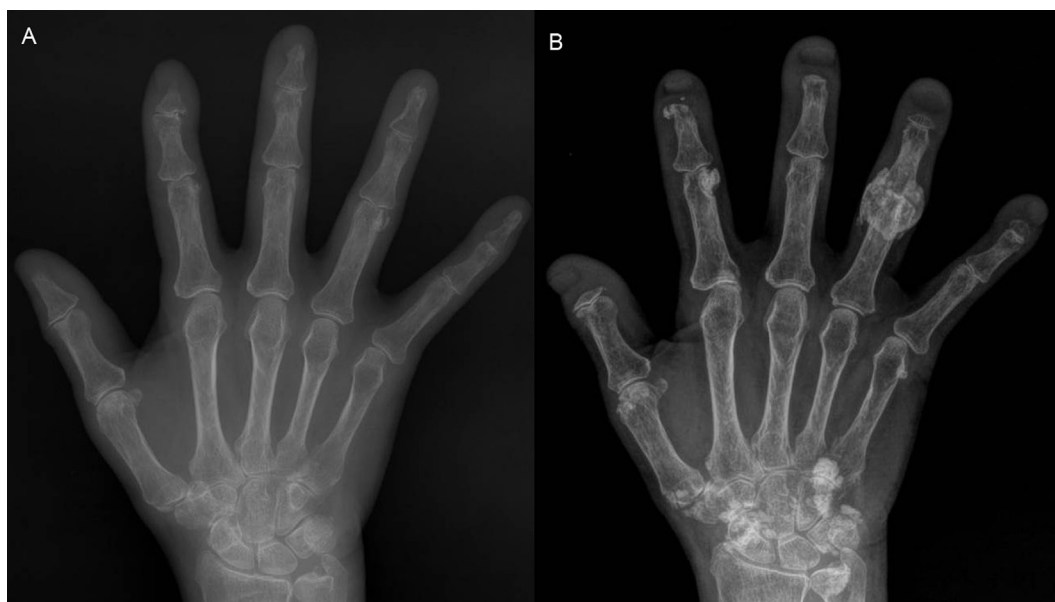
(A) Initial radiography of the patient's right hand showing mild osteolytic lesions of the 1st and 2nd distal phalanges with joint space narrowing in several interphalangeal joints. (B) Only two years later, aggravating acro-osteolysis is evident in all distal phalanges with multiple calcifications observed.
